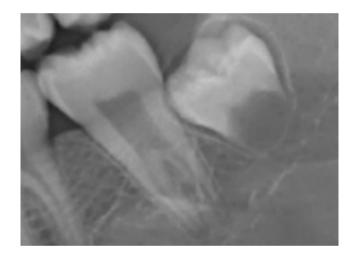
Cropped panoramic radiograph showing a taurodontic tooth 37 [FDI] and developing 38. These cases are challenges for forensic age assessment as the developmental behavior of tooth 38 cannot be reliably classified today.
